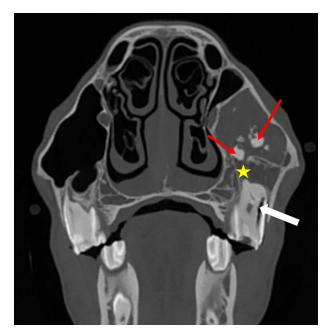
CT image showing features of an apical infection with decreased density indicative of gas (white arrow), an interruption of the lamina dura (yellow star), and dystrophic mineralizations (red arrows).
